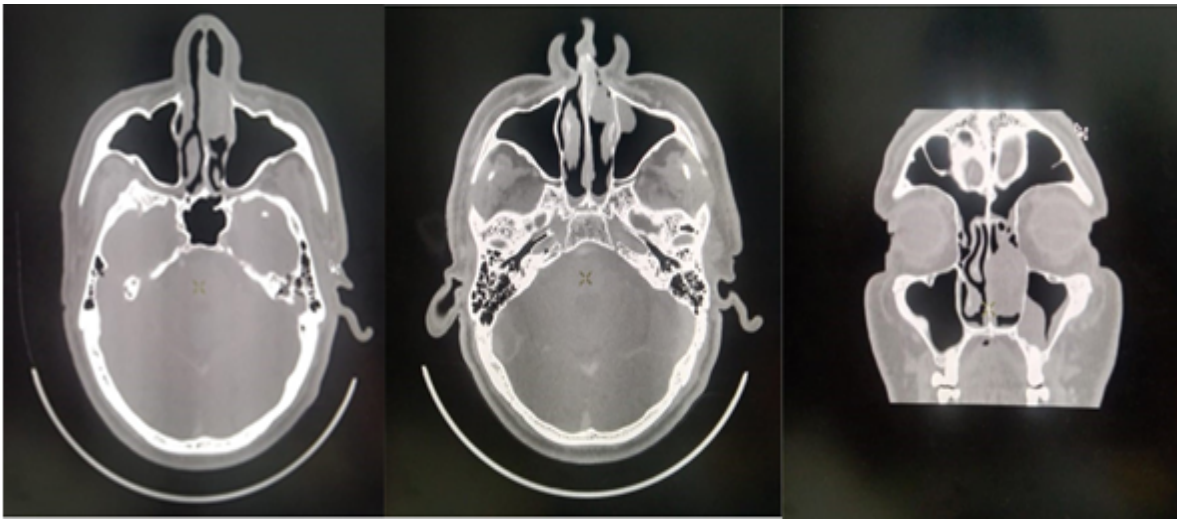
Axial CT sections clearly showing paranasal sinuses and benign looking mass in the left sided nose, abutting and scalloping the lateral and medial walls of the nose.
